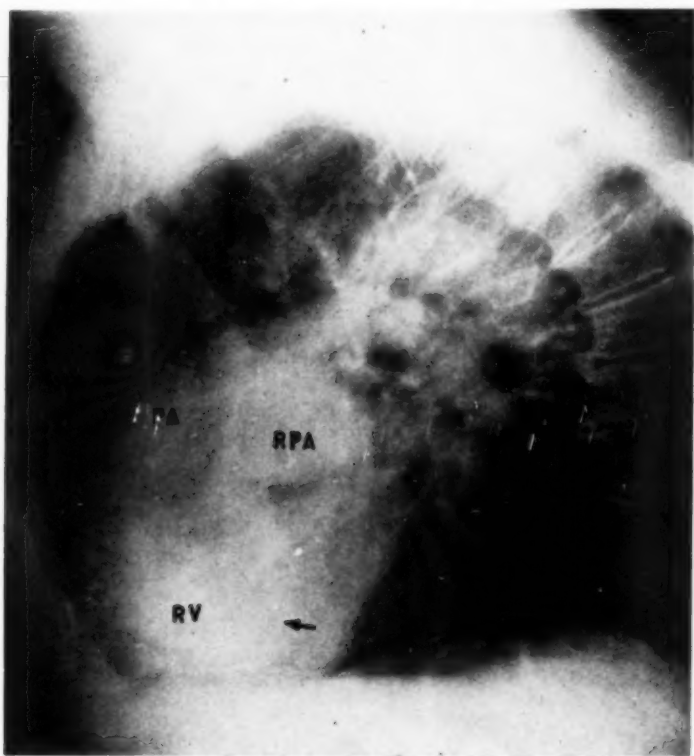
Cor Pulmonale*. Male, 71. Dyspnea, cough for many years. Physical and roentgen examination revealed marked pulmonary emphysema. *Left lateral angiogram*. Note opacification of markedly enlarged right atrium, right ventricle (RV), pulmonary artery (PA) and its branches. Right pulmonary artery (RPA) is seen end-on. Arrow indicates interventricular septum.
